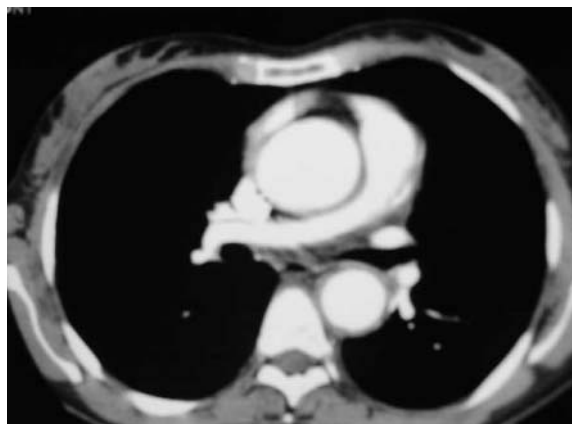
Takayasu's arteritis with pulmonary arteritis: CT scan with contrast showing thickening of pulmonary arterial wall and thickening of the aortic wall with dilatation of both the ascending and descending aorta.
